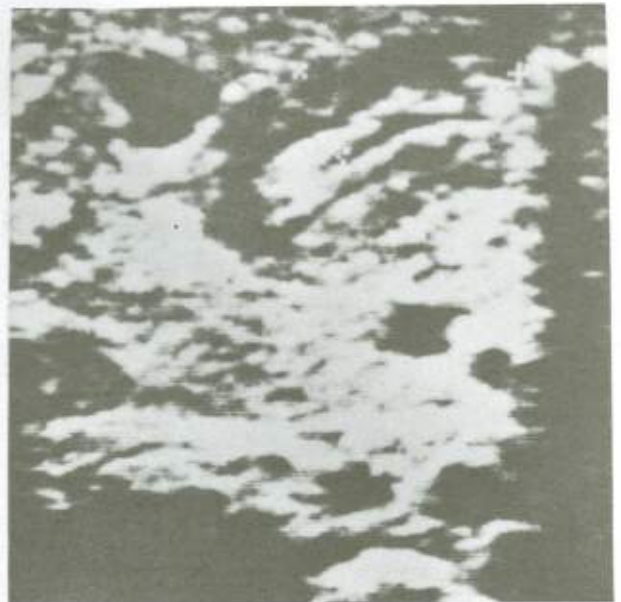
Longitudinal ultrasound scan of IHPS. Note the markers measuring the length and thickness of the pylorus.
